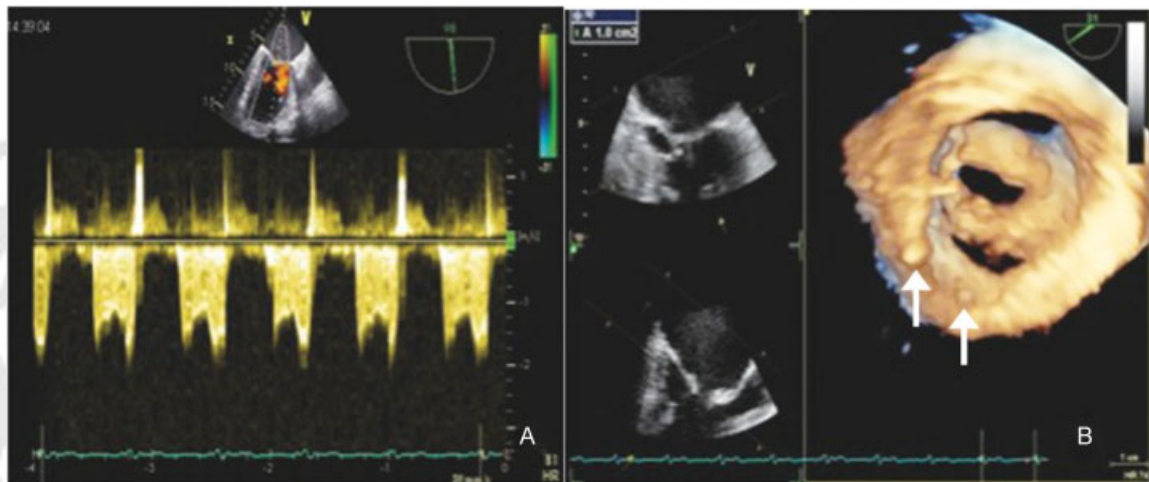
(A) Three-dimensional (3D) transesophageal echocardiography showed diastolic gradients of moderate-to-severe mitral stenosis and (B) 3D valve area with small calcifications (arrows) and thickening of the leaflet cusps. A spontaneous echo-contrast in left atrium and its appendage could also be noted.
